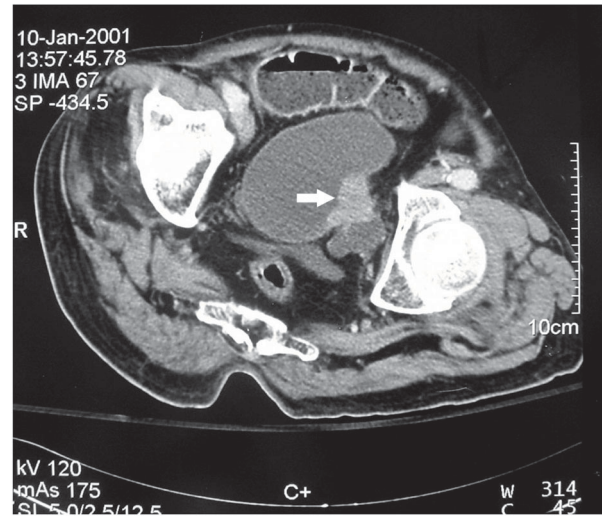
CT scan of the pelvis: Bladder mass (arrow) with extension into the perivesicular area
